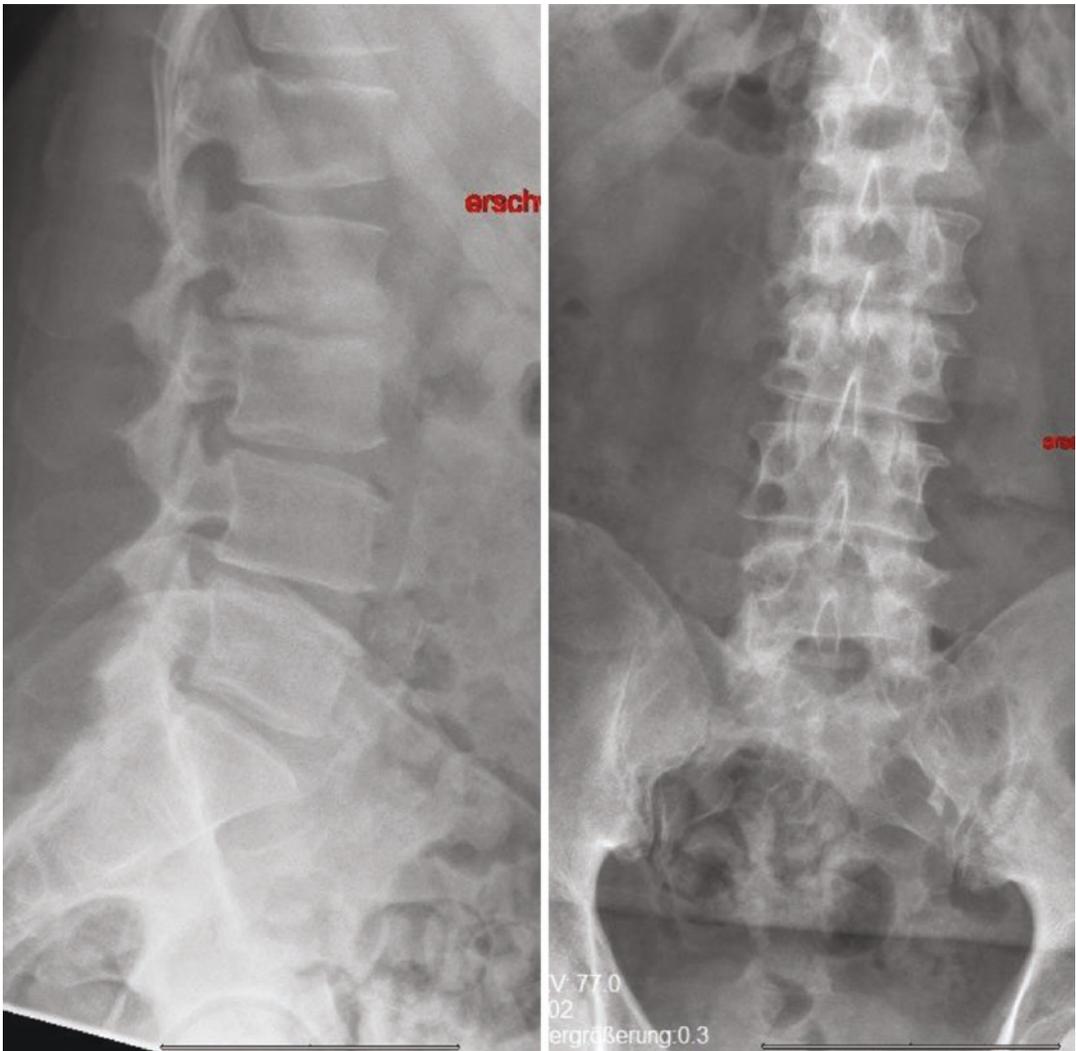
x-ray ap and lateral view
